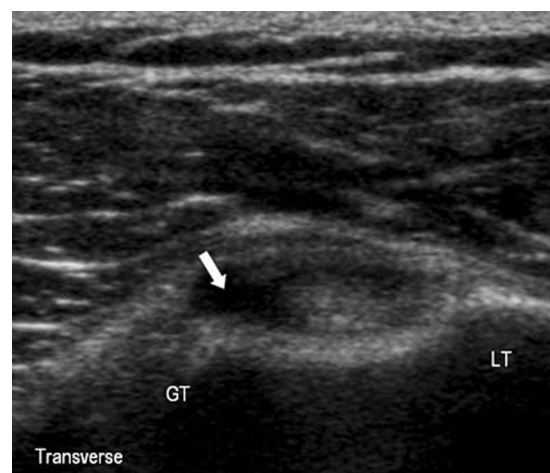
Transverse sonogram of the bicipital tendon, depicting tendinosis with effusion within its sheath (arrow). GT, greater tuberosity of humerus; LT, lesser tuberosity of humerus.
